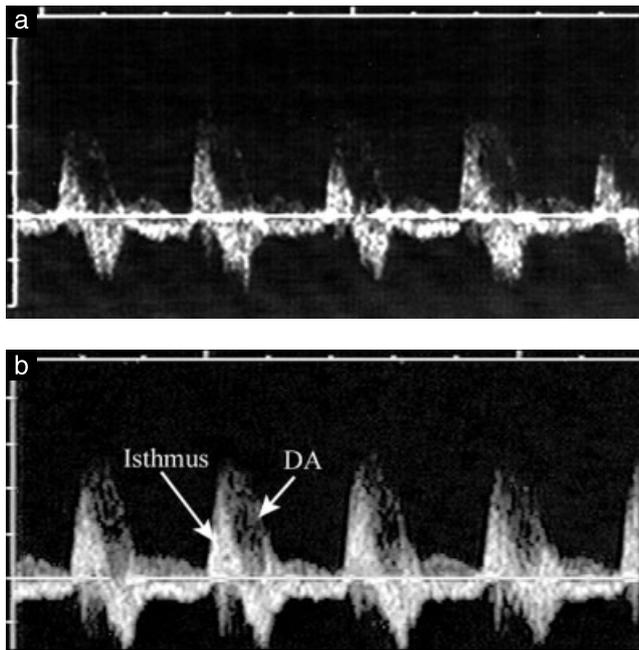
(a) Doppler flow pattern in the aortic isthmus of a 35-week fetus with cerebral arteriovenous fistulae. Note the retrograde flow after a brief systolic forward ejection wave. (b) A simultaneous recording of the velocity waveforms of both the ductus arteriosus and aortic isthmus of the same fetus demonstrates that, because of the marked increase in volume flow through the pulmonary arch, flow reversal through the isthmus occurs as early as mid-systole.
